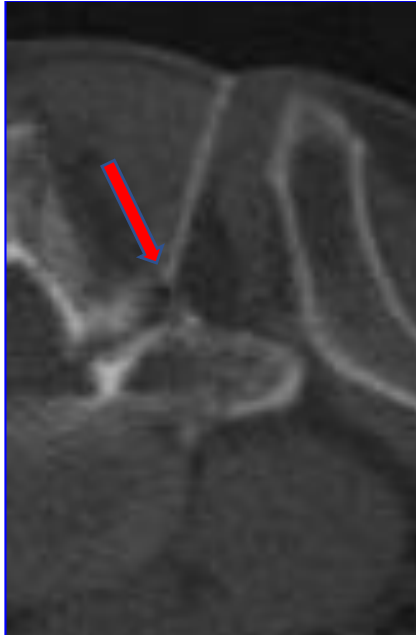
Intraprocedural CT scan with a bone algorithm confirms the correct positioning of the needle tip in close proximity to the isthmic lysis (arrow).
